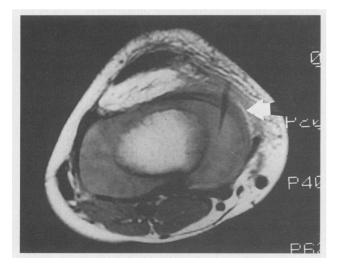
The patient's T2-weighted transverse plane magnetic resonance image shows a conical foreign body signal in the cartilaginous tibial epiphysis that was initially interpreted as artifact.
